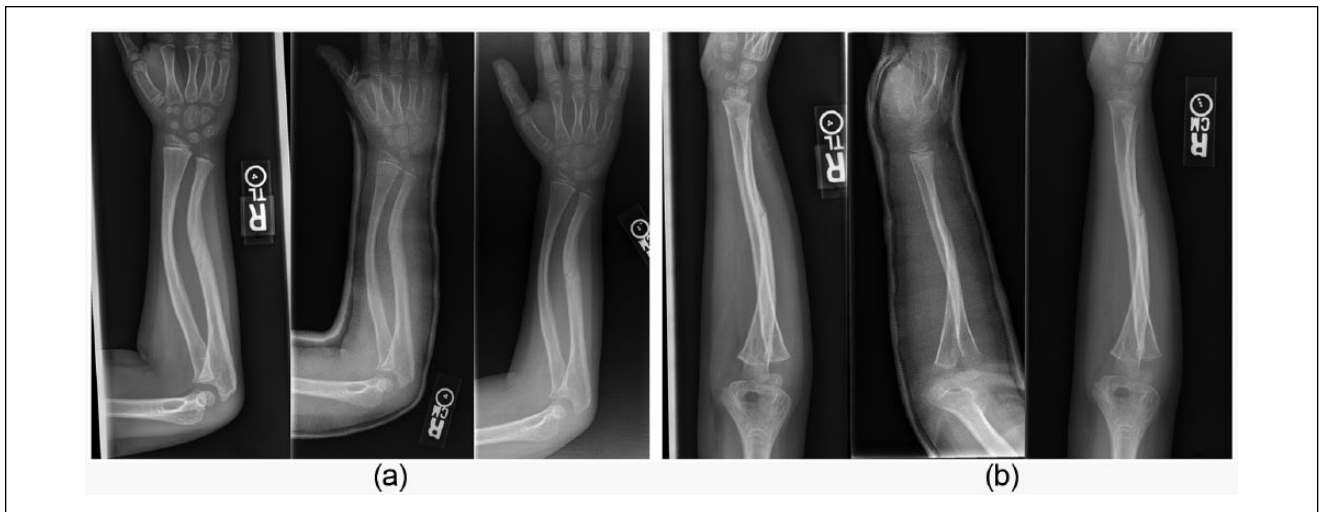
Radiographs after the patient sustained his initial injury. (a) Anterior-posterior and (b) lateral radiographs of both-bone forearm fracture, sustained by a 7-year-old boy, treated in a long-arm cast. Radiographs shown are at the time of injury, 2 weeks, and 4 weeks, respectively.
